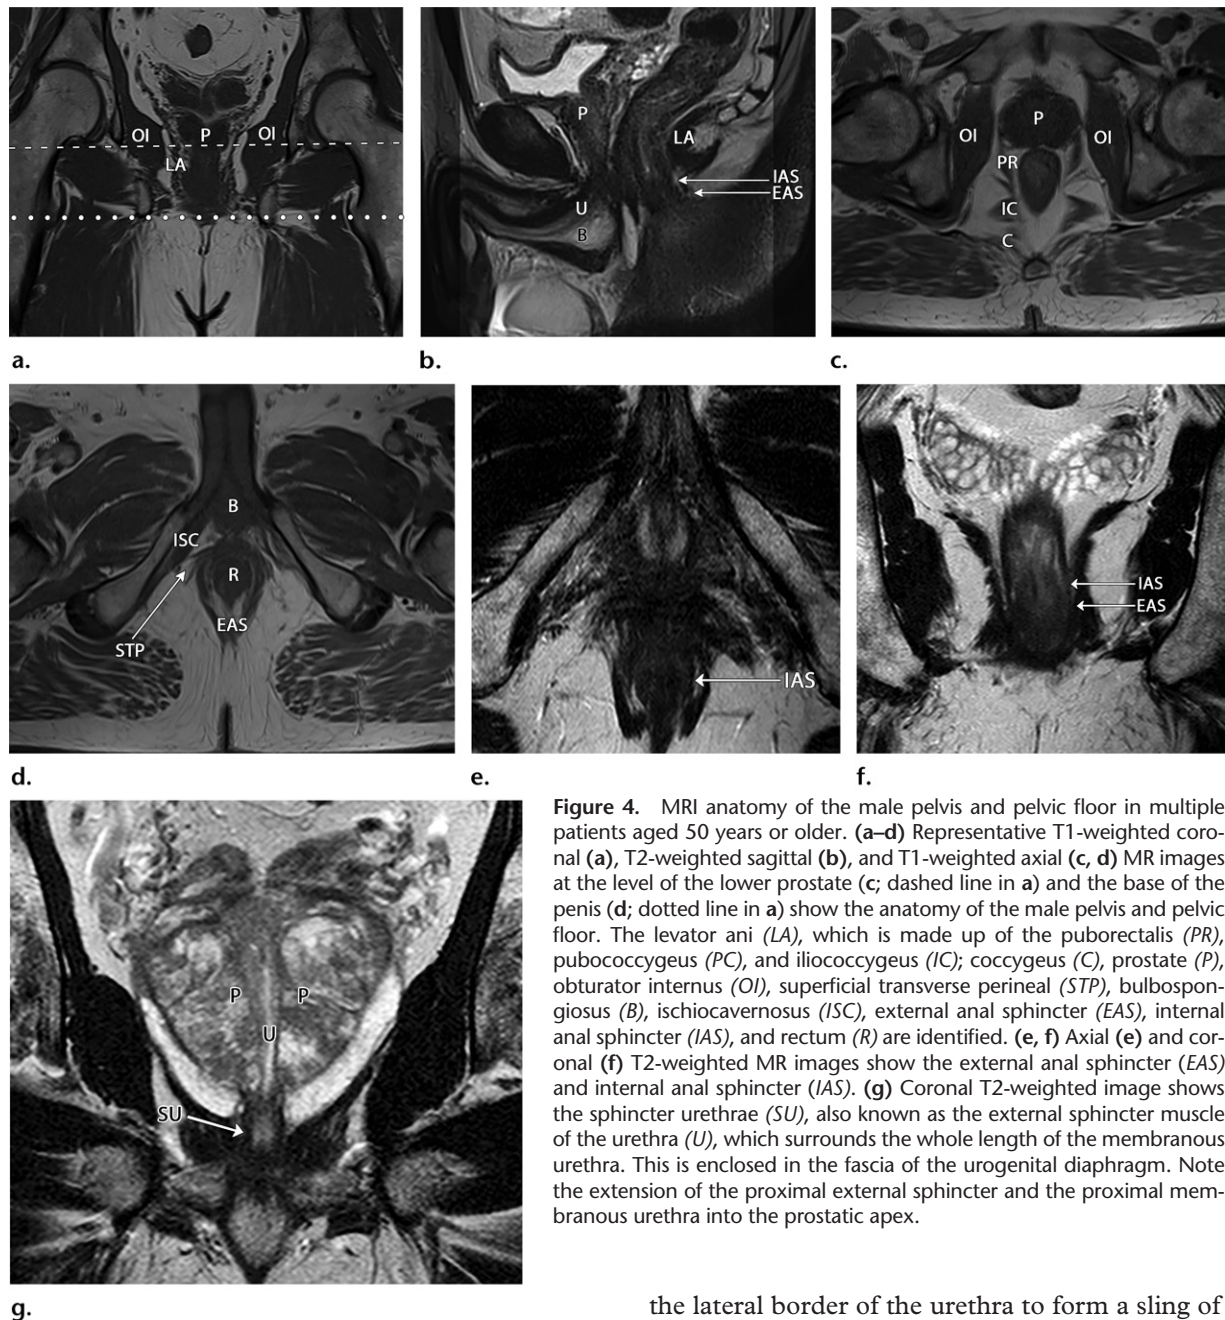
MRI anatomy of the male pelvis and pelvic floor in multiple patients aged 50 years or older. (a–d) Representative T1-weighted coronal (a), T2-weighted sagittal (b), and T1-weighted axial (c, d) MR images at the level of the lower prostate (c; dashed line in a) and the base of the penis (d; dotted line in a) show the anatomy of the male pelvis and pelvic floor. The levator ani (LA), which is made up of the puborectalis (PR), pubococcygeus (PC), and iliococcygeus (IC); coccygeus (C), prostate (P), obturator internus (OI), superficial transverse perineal (STP), bulbospongiosus (B), ischiocavernosus (ISC), external anal sphincter (EAS), internal anal sphincter (IAS), and rectum (R) are identified. (e, f) Axial (e) and coronal (f) T2-weighted MR images show the external anal sphincter (EAS) and internal anal sphincter (IAS). (g) Coronal T2-weighted image shows the sphincter urethrae (SU), also known as the external sphincter muscle of the urethra (U), which surrounds the whole length of the membranous urethra. This is enclosed in the fascia of the urogenital diaphragm. Note the extension of the proximal external sphincter and the proximal membranous urethra into the prostatic apex.
